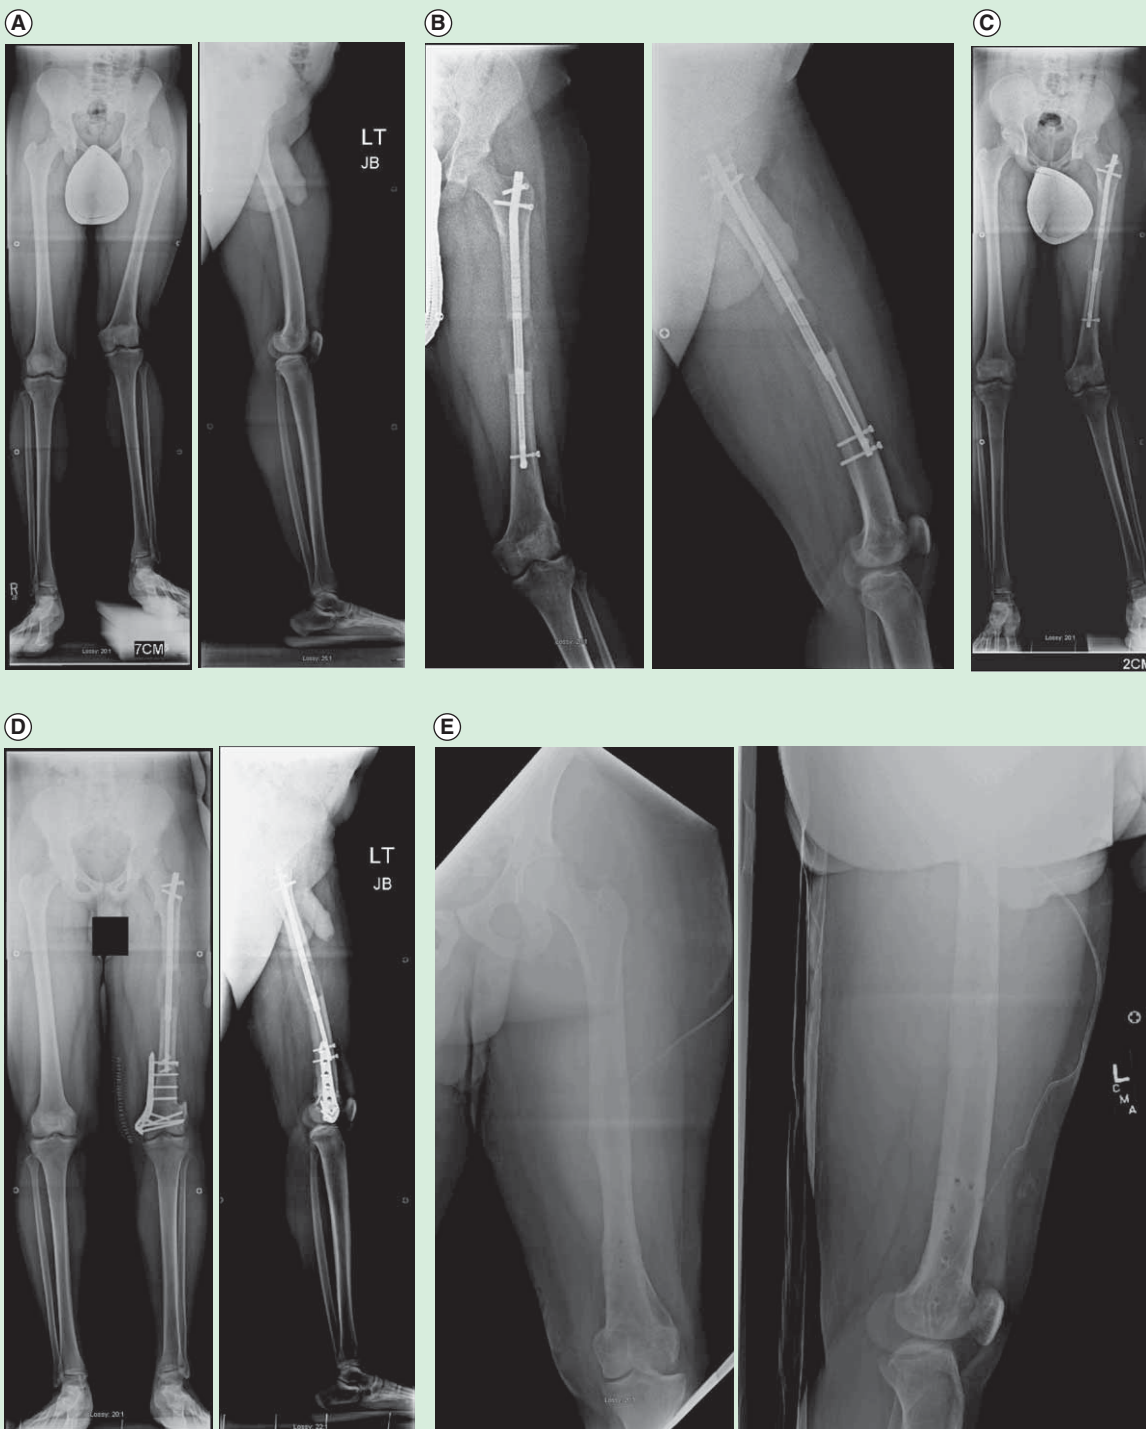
Sixteen year old boy with a leg length discrepancy and valgus deformity secondary to a partial growth arrest of the distal femur (developmental etiology). (A) Preoperative AP and lateral radiographs (B) AP and lateral radiographs after 6.5cms lengthening using a 10.7mms trochanteric entry Precice1 tibial nail (we used a tibial nail since at the time the trochanteric entry femoral nail was unavailable; the current P2 tibial nail has a shorter magnet and would not be a good choice to use but the P1 tibial nail had the regular length magnet and could be used in the femur). This was our very first Precice case in December 2011. (C) AP radiograph showing the worsened valgus deformity after 6.5cms of lengthening. (D) AP and lateral radiographs after acute correction of the valgus deformity by a medial closing wedge osteotomy with internal fixation using a locking plate. A peroneal nerve decompression was also done to minimize the risk of nerve stretch injury. (E) The final AP and lateral radiographs after removal of all of the hardware a year later.
